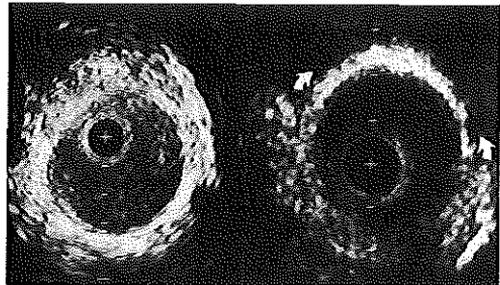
Intravascular ultrasound cross-sections showing the differences between images obtained during the semiclosed and the open technique. Left panel: Using the semiclosed technique the tissue surrounding the vein wall can be identified completely. Right panel: Using the open technique the effect of exposure of the vein to air is seen on ultrasound between 9 and 3 o'clock (arrows) as a more hyperechoic outer layer than seen between 3 and 9 o'clock. + = Catheter; calibration = 1 mm.
